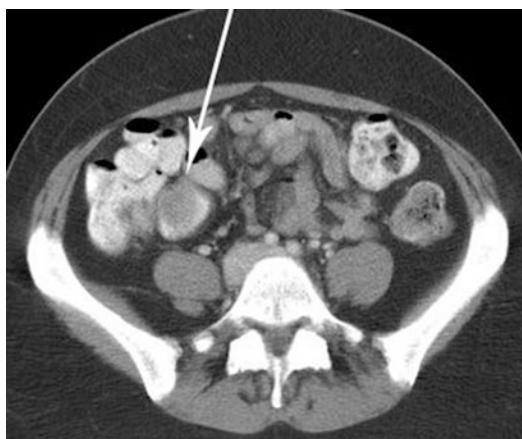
Axial CT image of the pelvis with oral and IV contrast of a 46-year-old woman presenting with GI bleeding and abdominal pain. A filling defect was identified in the terminal ileum (white arrow). At surgery, a polypoid-shaped endometriosis deposit was diagnosed in this location
